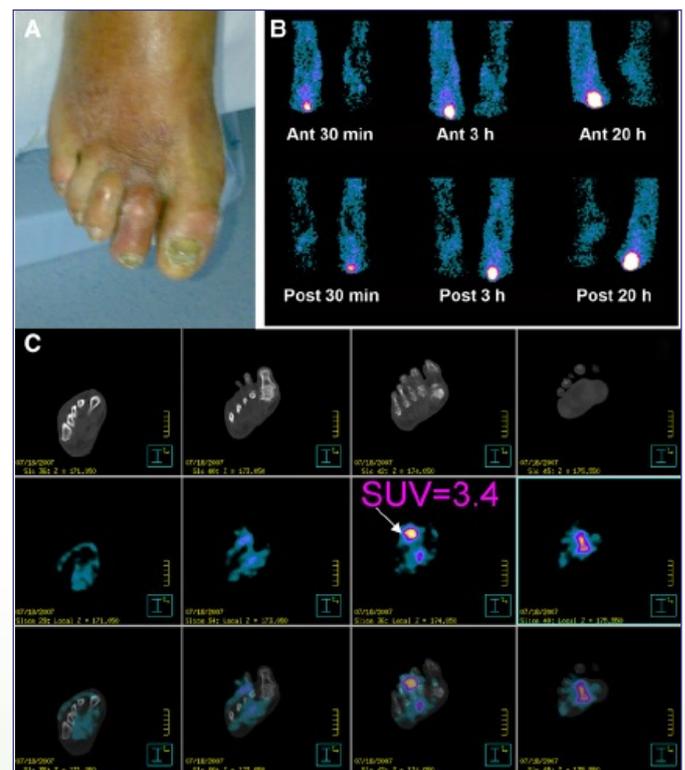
Positive scan results for diabetic foot infection: WBC scintigraphy (B) and  $^{18}\text{F}$ -FDG PET/CT (C); with courtesy of Familiari et al (34).
